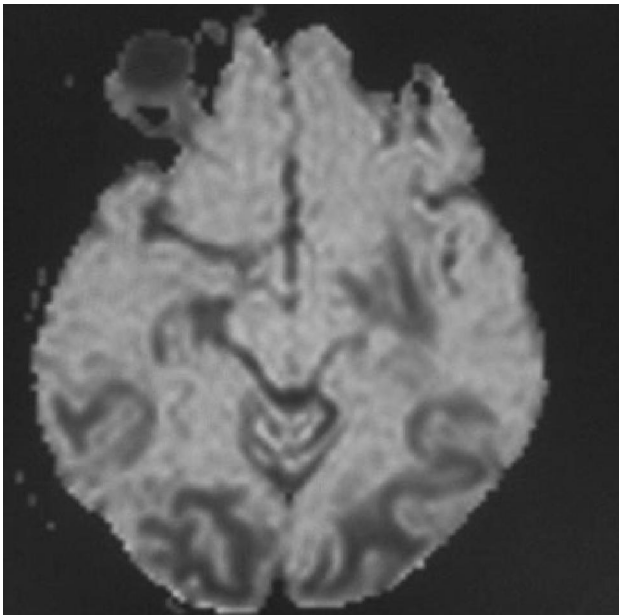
T2 weighted MR image showing hyperintense focal lesions of similar patient in Fig 4.
